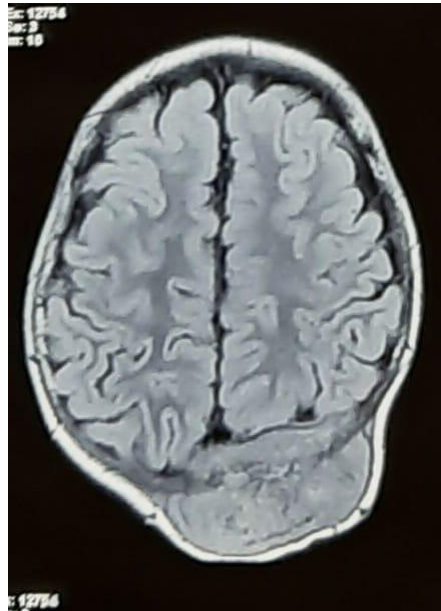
CT scan of the brain showing a occipital-parietal tumor
